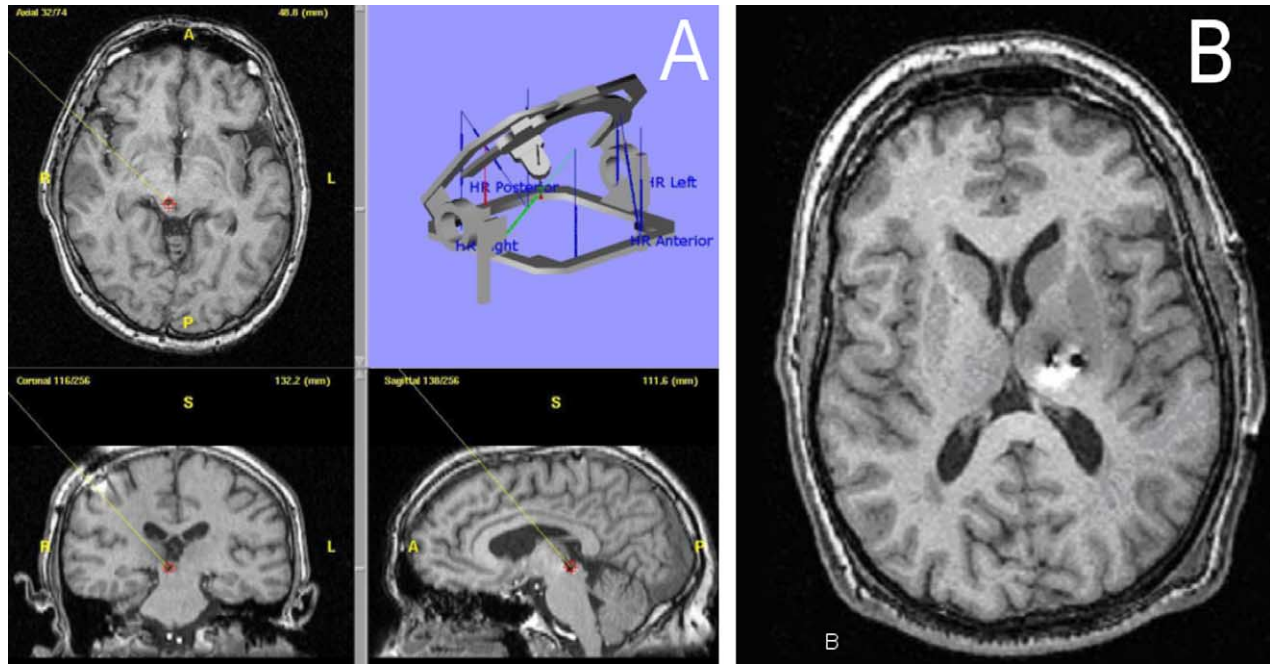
(A) The screen view showing the planned trajectory and targeting of the PVG/PAG in three planes. (B) A POST-operative MRI showing the VPL electrode (lateral) and the wire leading to the PVG electrode (medial) which is located inferiorly.
